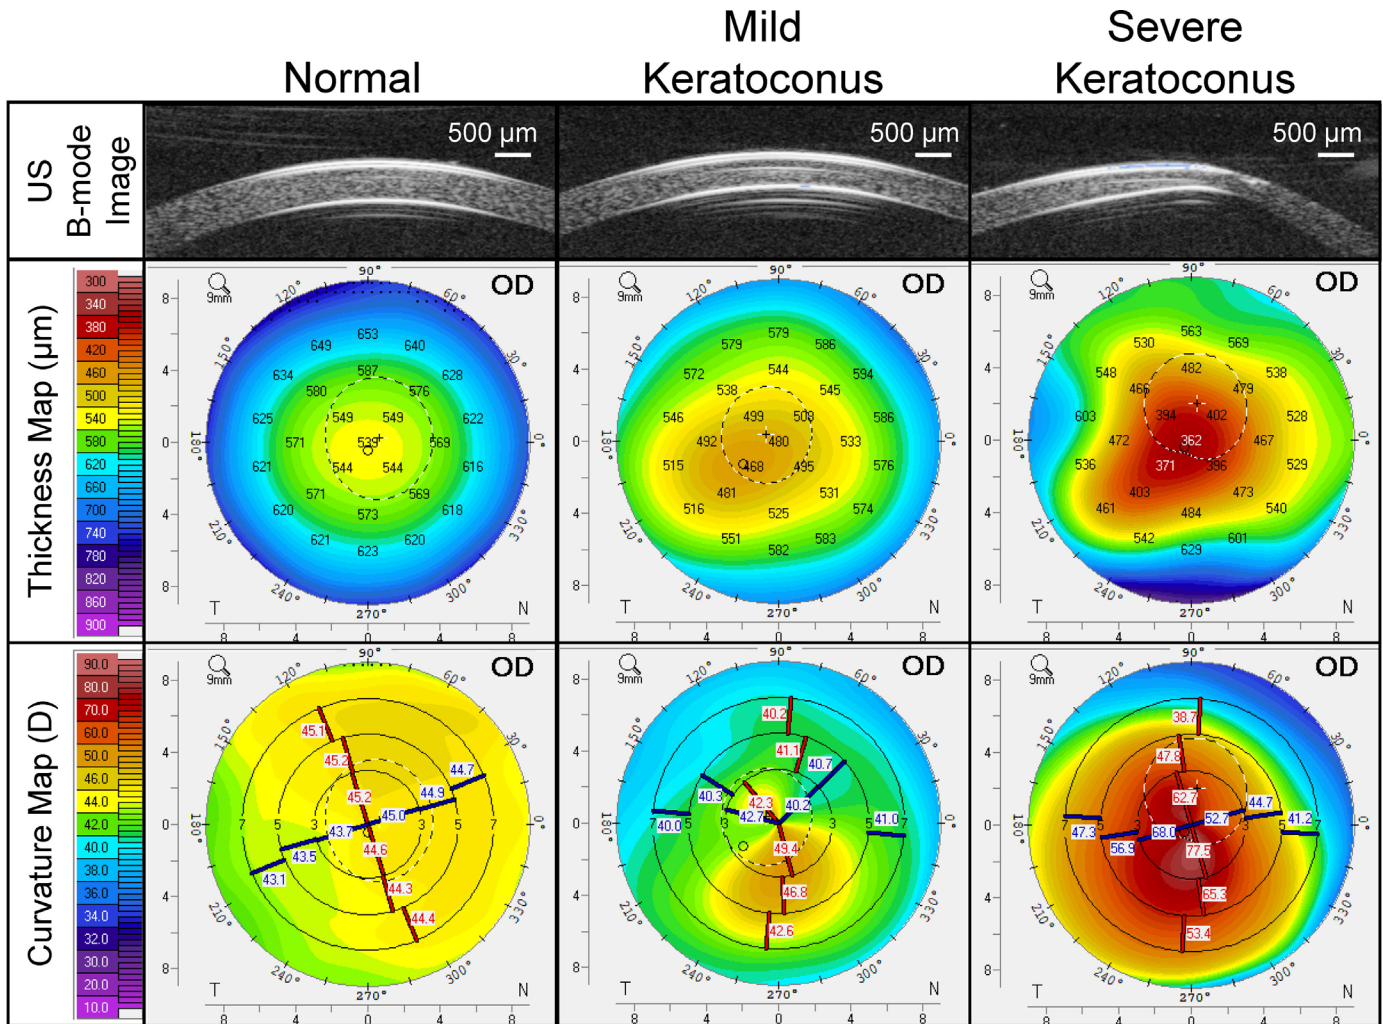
High-frequency ultrasound B-mode images of the central 5.7 mm of the cornea from a normal subject (*left*), grade-2 keratoconus (*middle*), and a patient with grade-4 keratoconus (*right*), along with their corresponding thickness and curvature maps obtained by Pentacam.
